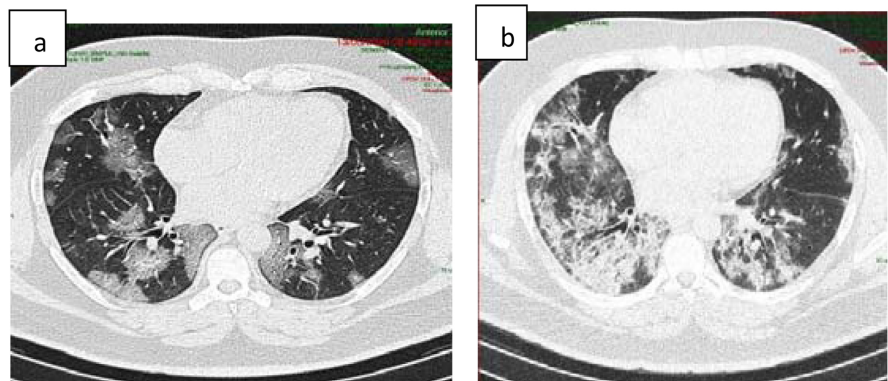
Evolution of the disease by the appearance of the lesions (a) Axial CT in the COVID-positive pulmonary window with ground-glass areas with subpleural distribution associated with septal and peribronchovascular thickening that give a cobblestone appearance characteristic of disease in progression phase. (b) Axial CT in COVID-positive lung window with areas of increased attenuation with air bronchogram and cottony appearance in both bases typical of advanced-stage.
